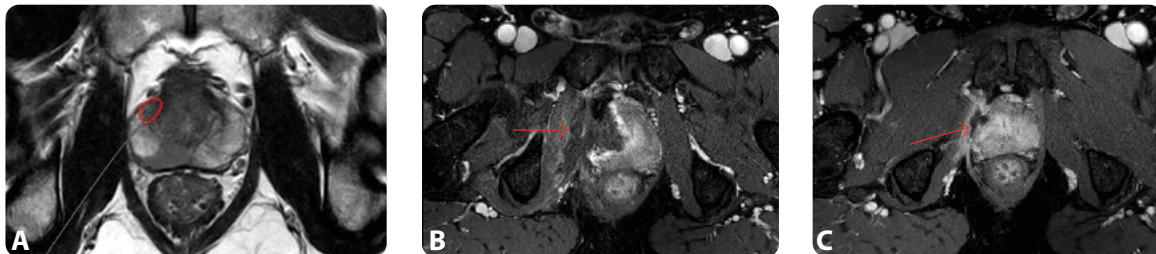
Patient with a non-advanced localized tumor (3 + 3 Gleason score) in the upper right aspect of the prostate with a dimension of 17.5x8.5x4.8 mm was treated with focal laser ablation. a) Target areas with altered MRI signal with suspicion for localized tumor before biopsy. Biopsy confirmed the cancerous lesion and the patient was treated with laser ablation. b) The axial MRI scan shows a large area of coagulative necrosis surrounded by a ring of hyperaemia 24 hours after laser ablation without complications. c) The axial MRI scan at 8 months after ablation shows a marked reduction of the induced necrotic area. Biopsies at 8 months after treatment were negative. *Images by courtesy of Dr. Stefano Regusci and Dr. Martina Martins (ImageRive La Colline, Geneva)*
